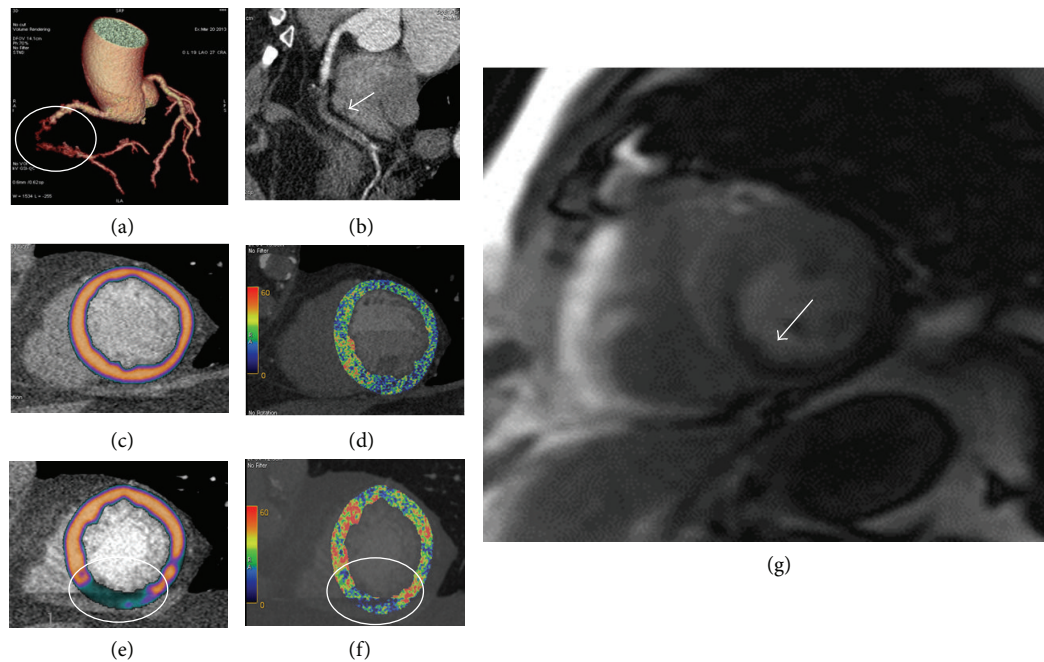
Clinical case of a 61-year-old man referred for suspected coronary artery disease. To rule out the presence of significant coronary artery disease and ischemia, a rest-stress dual energy CCT has been performed. The exam showed a chronic total occlusion of the right coronary artery (Panel (a) circle, Panel (b) arrow) due to a noncalcified plaque. The myocardial perfusion (Panel (c)) and iodine map (Panel (d)) at rest do not show significant perfusion defect. Under stress condition (i.v. adenosine injection), dual energy computed tomography showed a large perfusion defect in inferior wall of left ventricle (Panel (e) and (f), circle) with good matching as compared to stress cardiac magnetic resonance (Panel (g), arrow). CCT: cardiac computed tomography.
